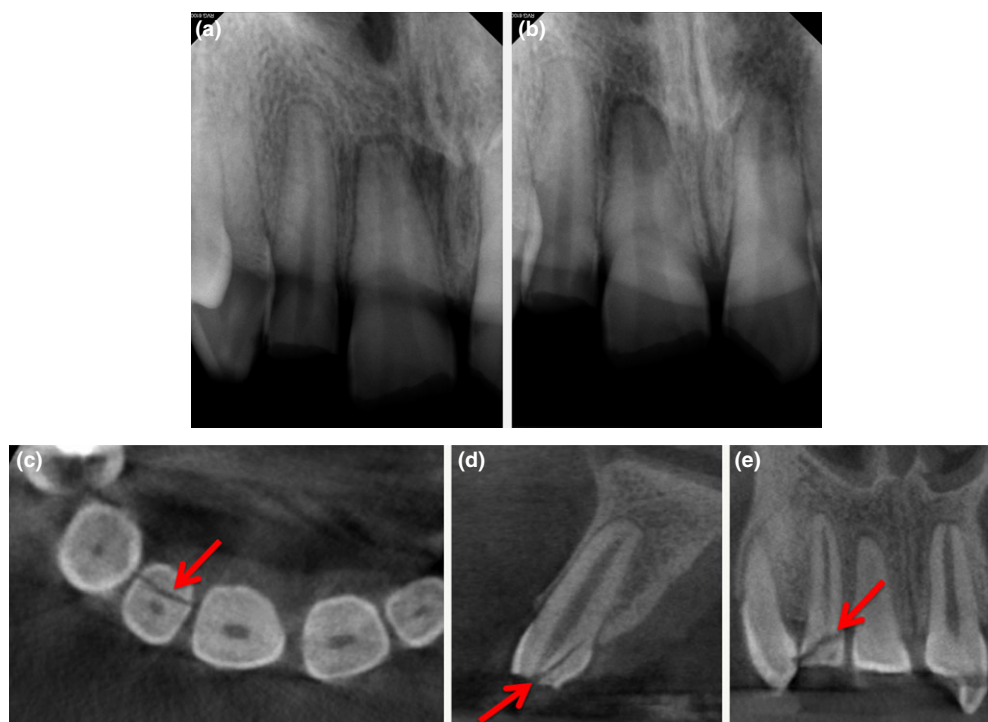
Radiographs taken to assess the upper central and lateral incisors after trauma. Periapical radiographs (a, b) only show evidence of complicated crown fractures. CBCT images (c, d, e) disclosed the presence and extent of a crown-root fracture (arrows).
